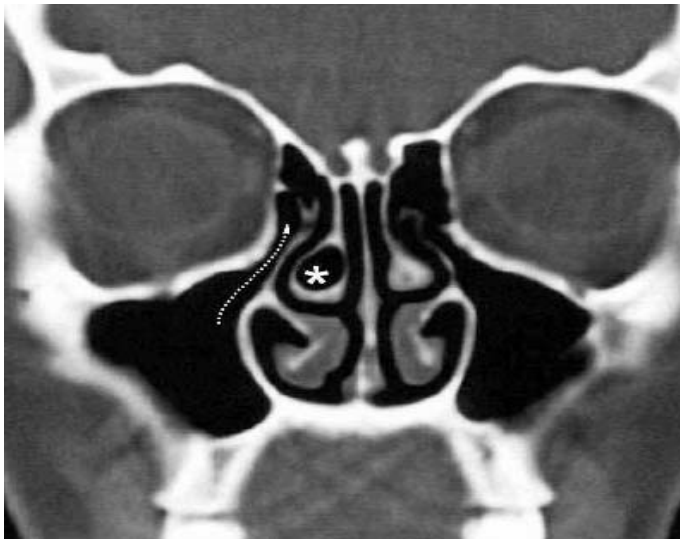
Bulbous type concha bullosa (*asterisk*) is present on the right in this CT study. Right ostiomeatal unit is open (*dashed arrows*).
